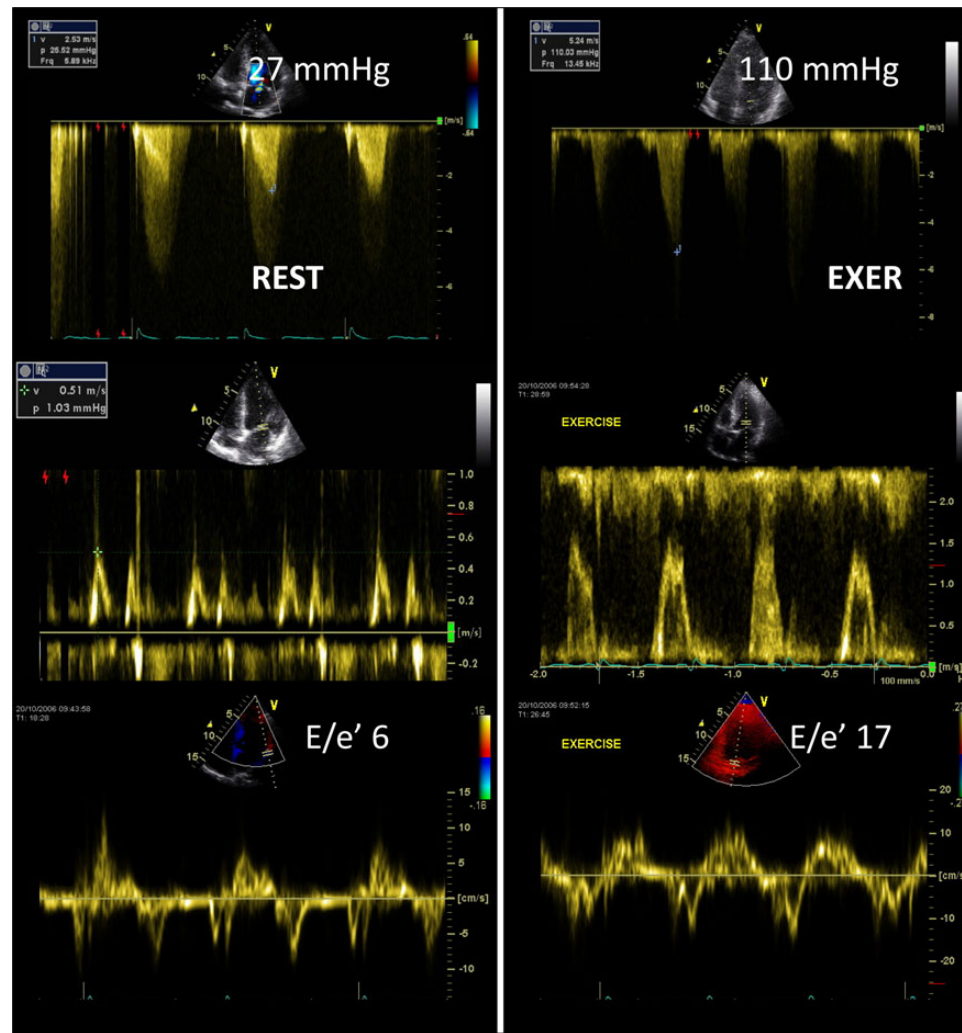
Dyspneic patient with HCM, increased dynamic intraventricular obstruction (top) and left ventricular filling pressure (bottom, E/e') during exercise echocardiography.
